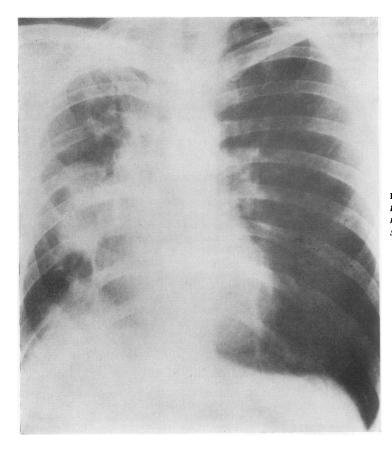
Case 5. Chest radiograph three years after right upper and middle lobectomy showing increased shadowing on right side.
